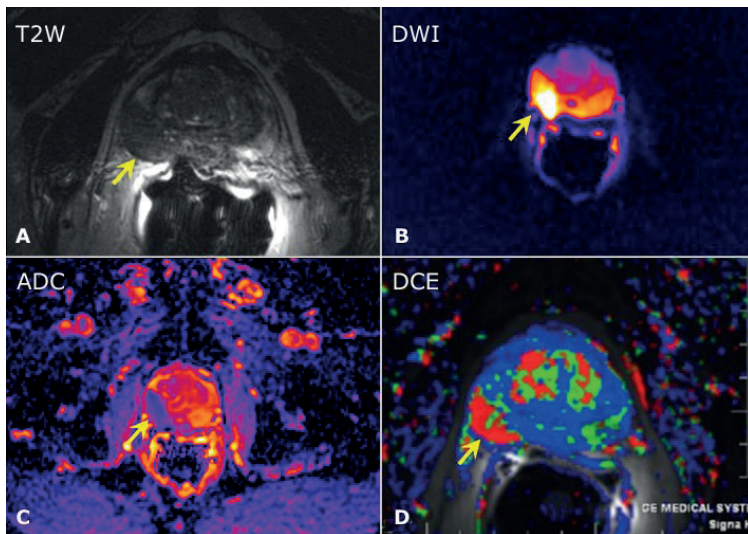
Multiparametric MRI of the prostate
